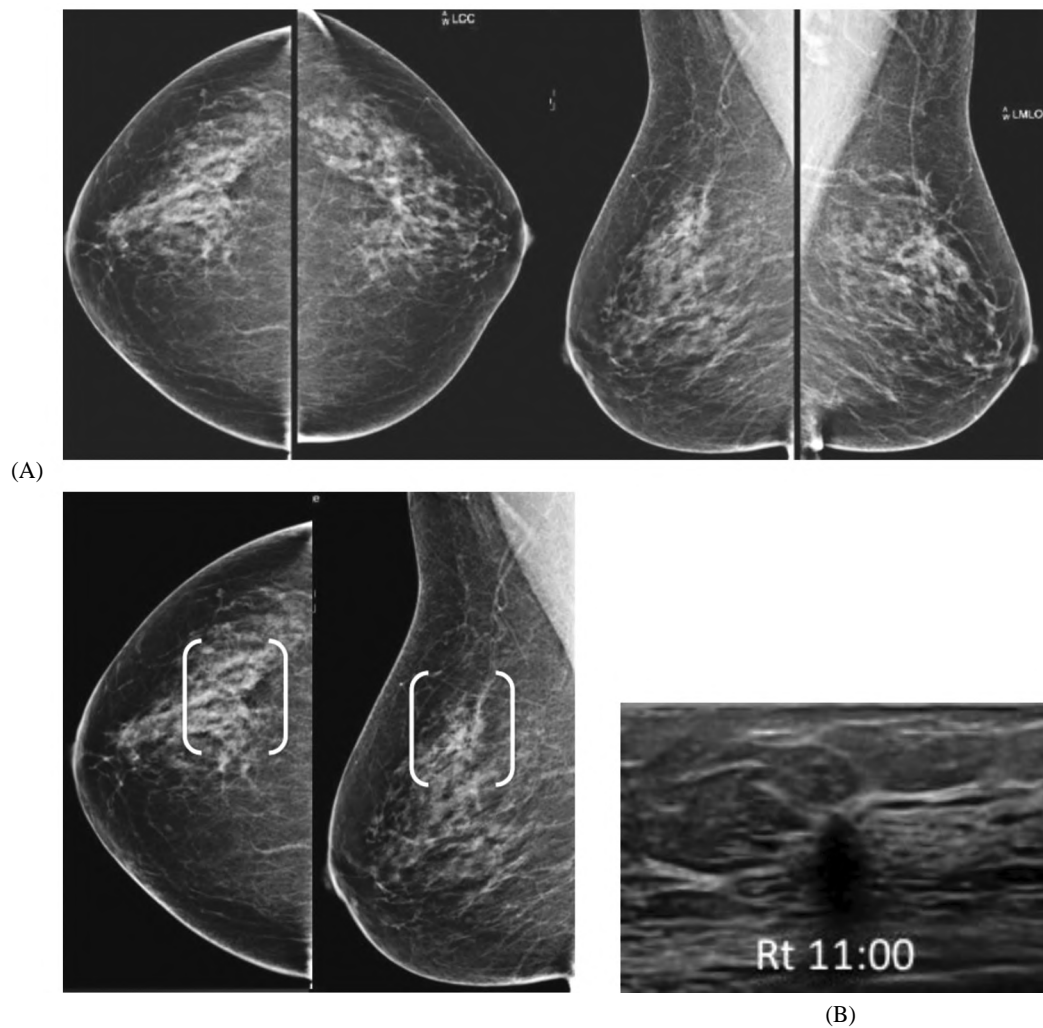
A 60 year old woman coming for her annual screening. (A) CC and MLO views of both breasts show subtle focal distortion in the UOQ of the right breast. (B) Complementary ultrasound of the right breast shows focal shadowing at 11 o'clock position. Biopsy was taken with final diagnosis of ILC.
